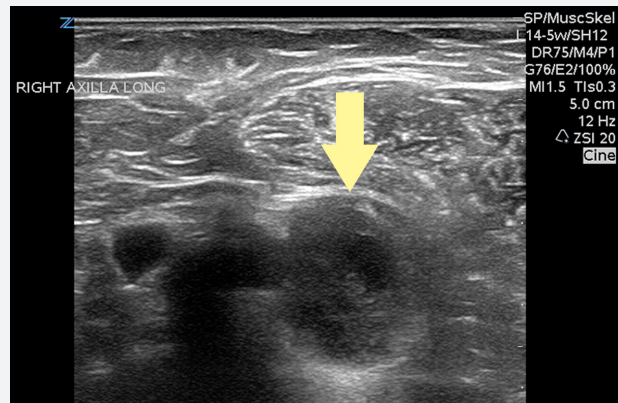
Sonographic image using a linear array transducer with a mean spatial harmonic operating frequency of 12 MHz demonstrates a hypoechoic lesion near the neurovascular bundle.
